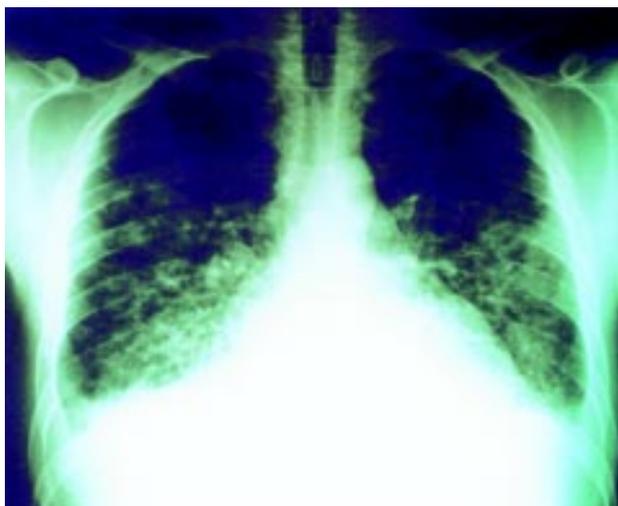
Chest X-ray showing increased cardiothoracic index with bilateral bronchoalveolar infiltrations and interstitial pneumonia
